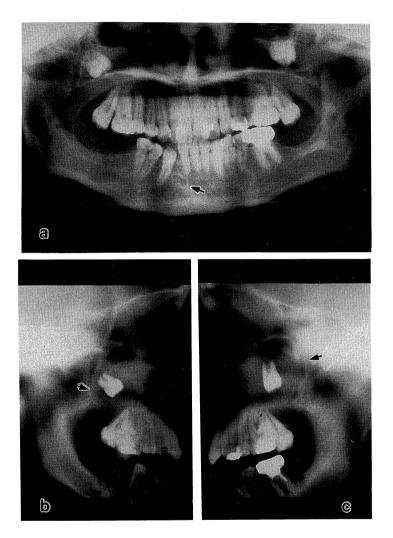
A panoramic radiograph(a) and tomograms of the maxilla(b: right, c: left) showed three well-defined, cystic radiolucencies in the mandibular right lateral incisor and both maxillary third molar regions (arrows)
